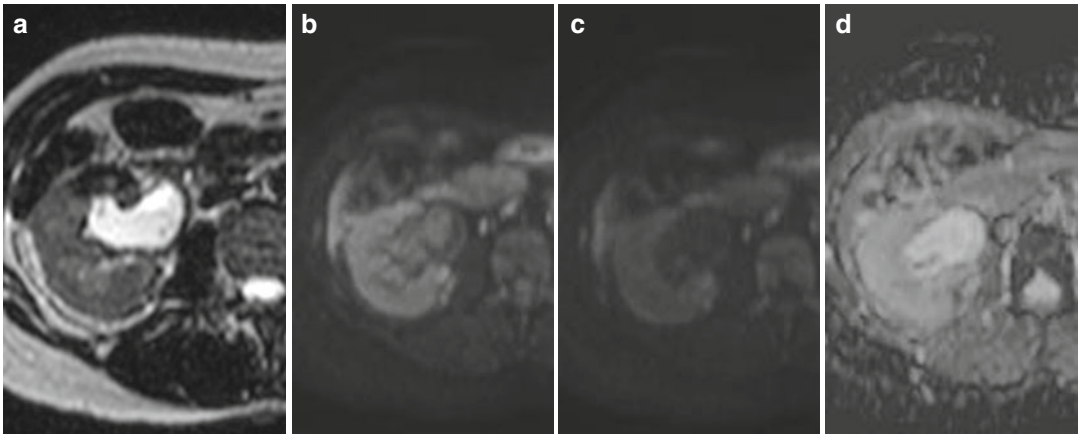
SE breath-hold image T2W-SENSE with a thickness of 3 mm (a) that shows the presence of a moderate dilatation of the right renal pelvis in a context of hydronephrosis, with only a slight inhomogeneity of signal; DWI with $b=500$ (b), signal intensity of the content of the renal pelvis comparable to that of the adjacent parenchyma, in relation to the $T2^*$ effect of urine that
